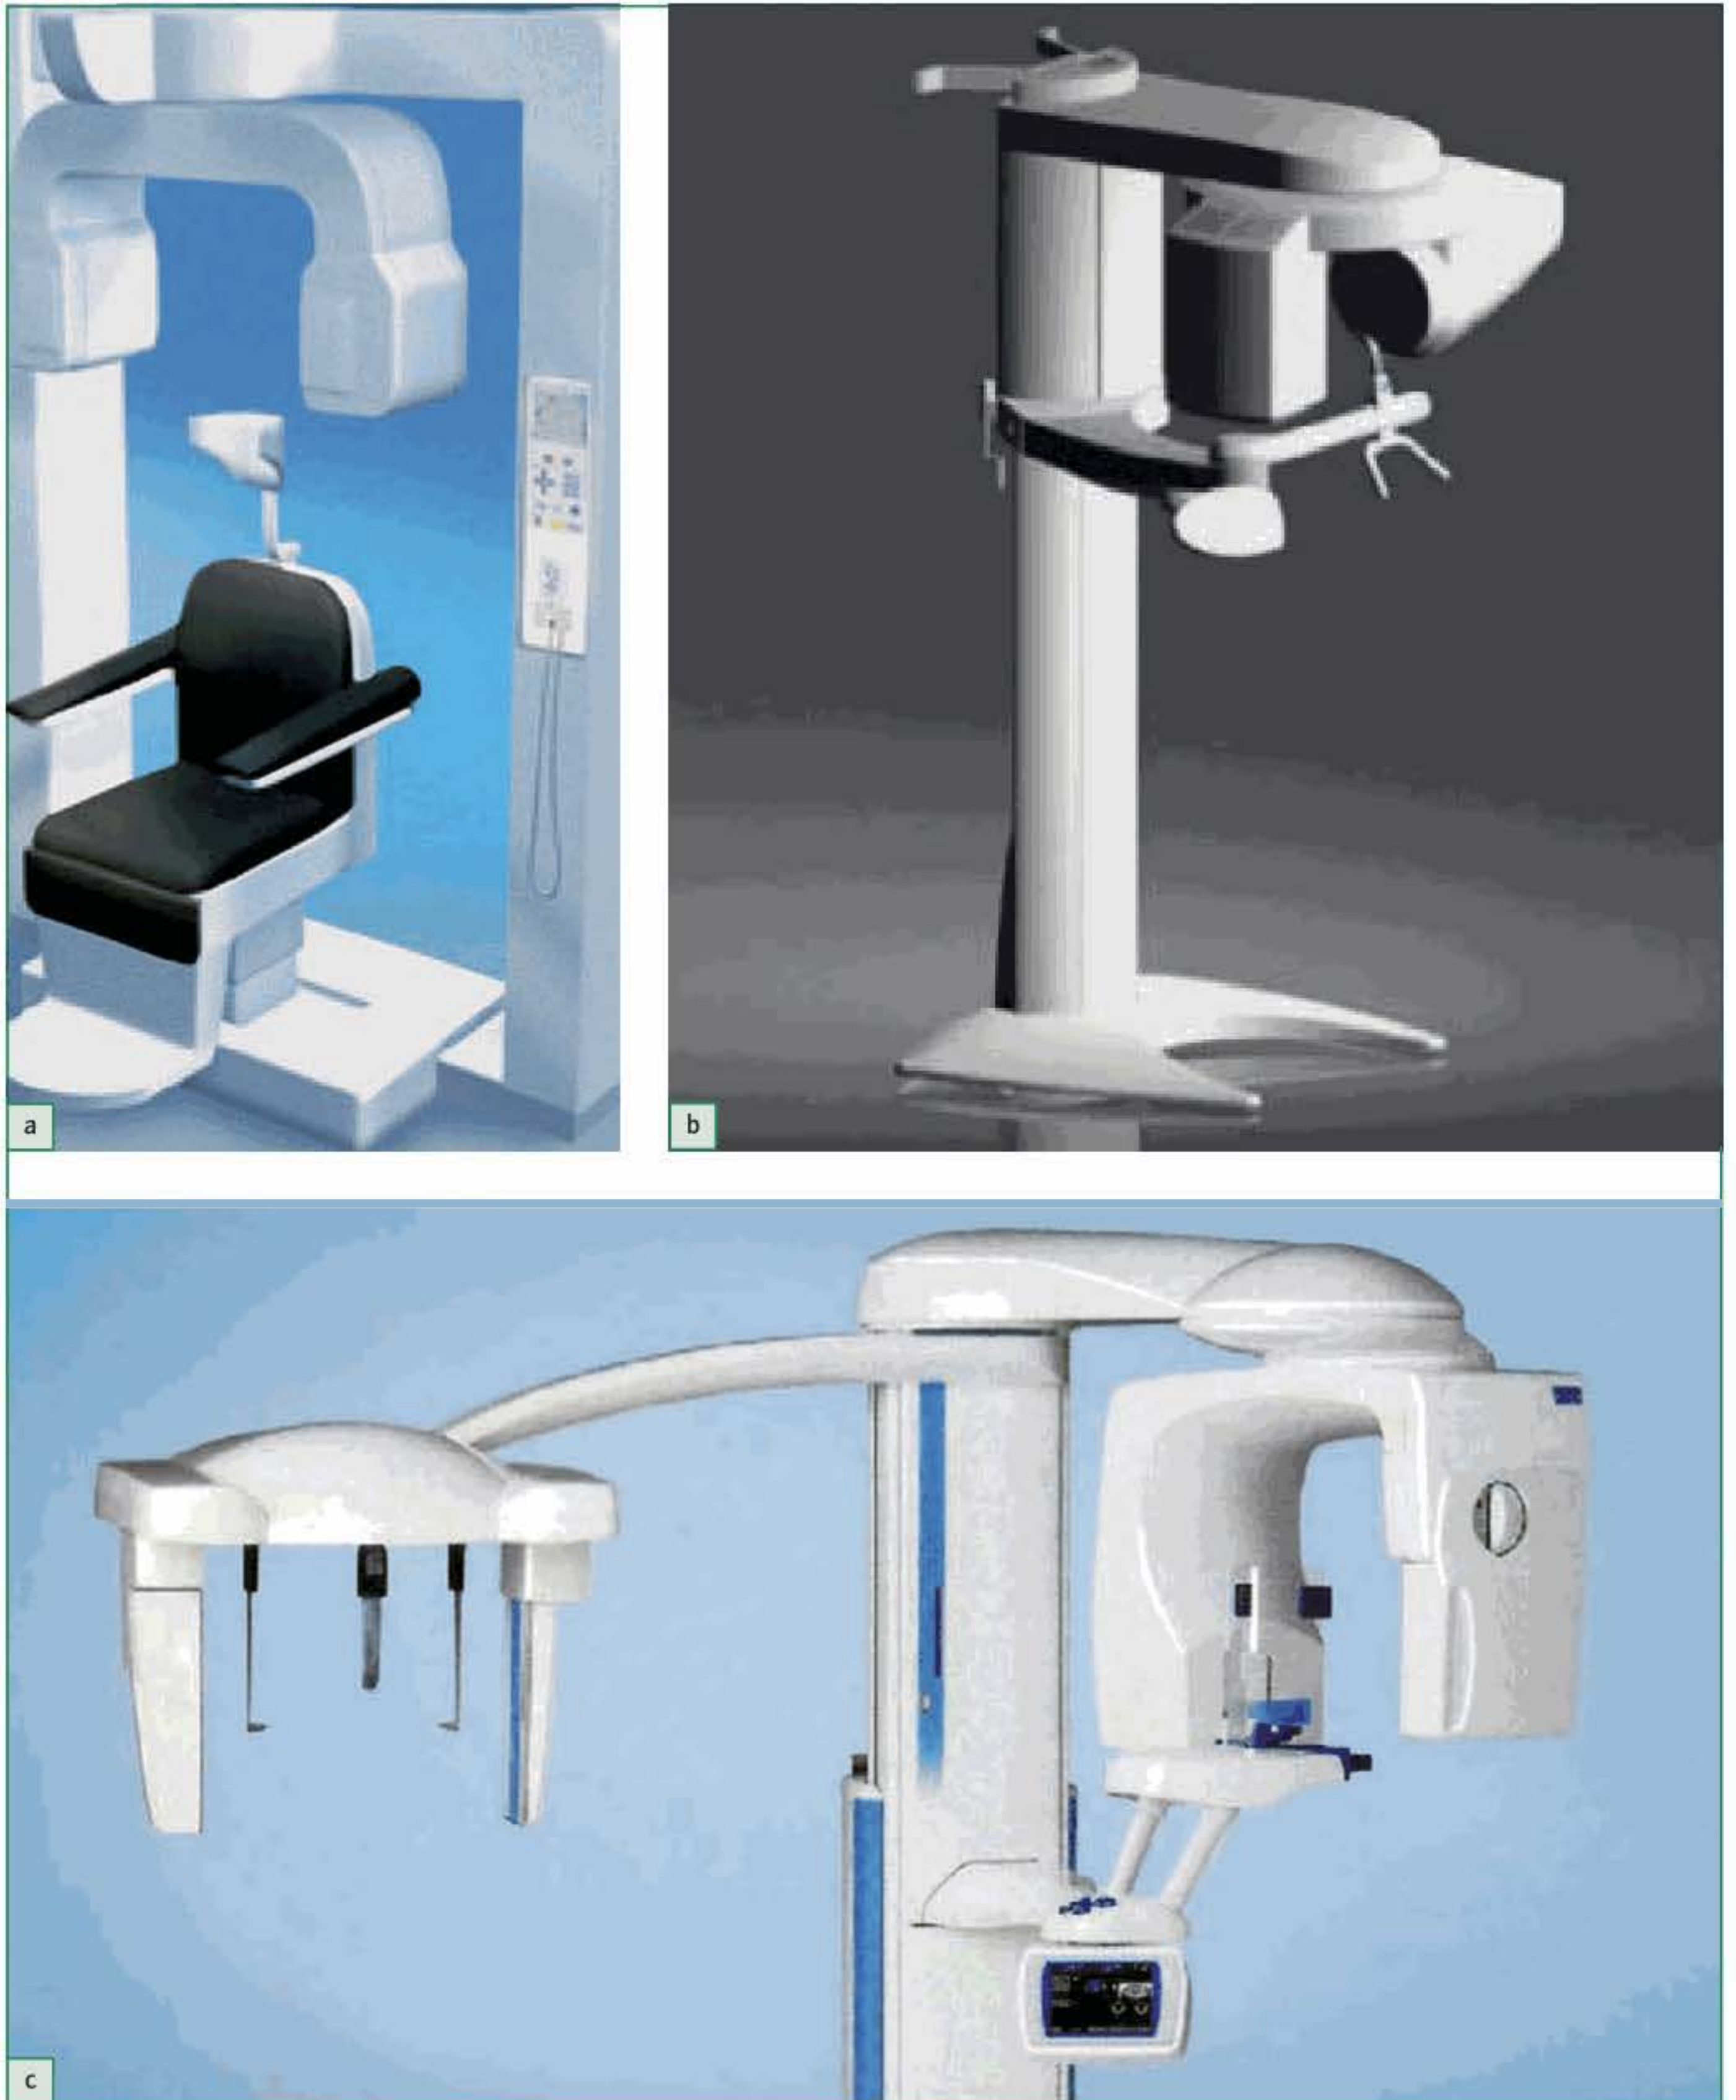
Cone-beam volumetric imaging systems in development or shortly before market entry. (a) Accuitomo from Morita; (b) GALILEOS from Sirona; (c) Promax 3D from Planmeca.
